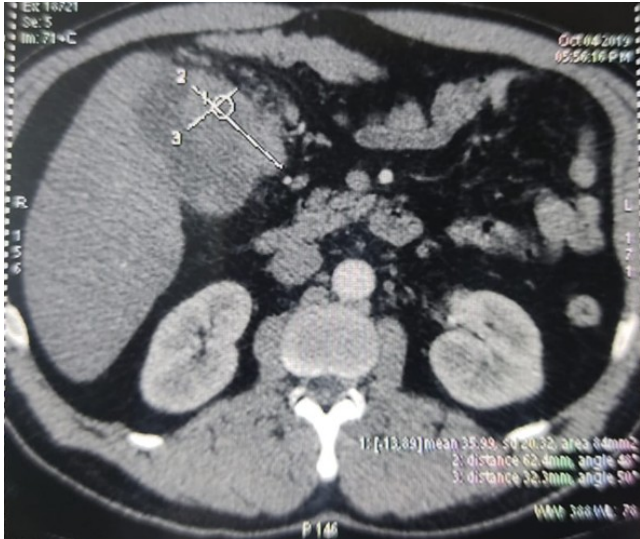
CT image of thickened gallbladder wall
